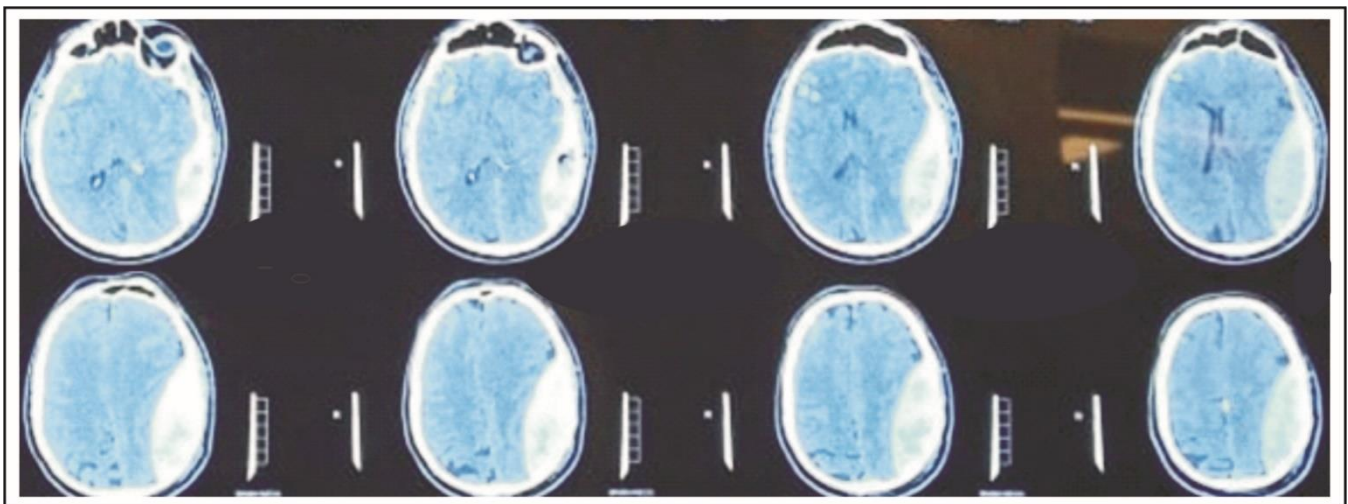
CT Scan of the patient at the time of presentation (Presented with patient's consent).
